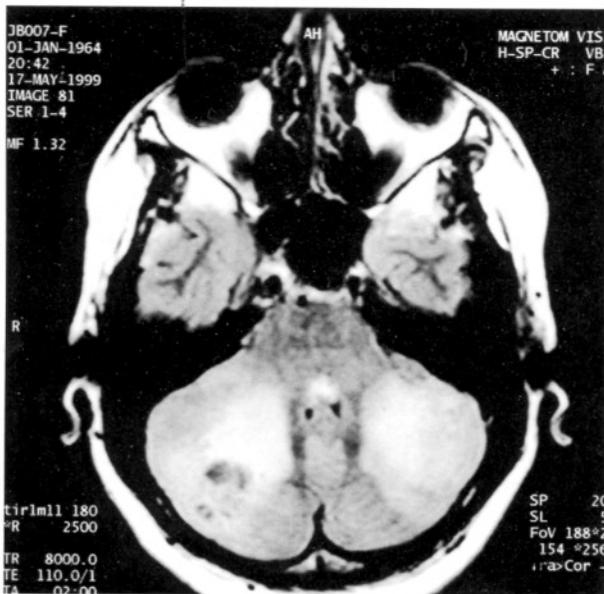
Axial T2-weighted MR scan shows, hyperintens cortico-subcortical lesions on both cerebellar hemispheres. There is no midline involvement.
